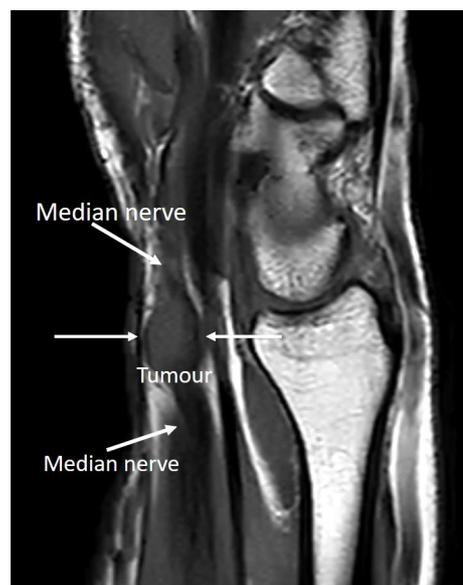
Magnetic resonance imaging of the tumour of the median nerve (sagittal view)
